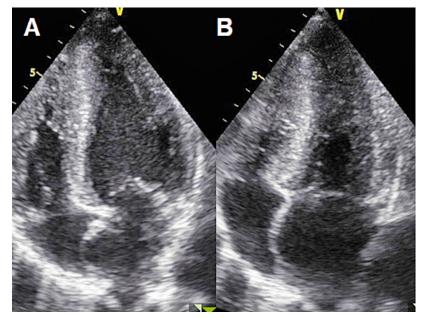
Transthoracic echocardiography, apical four-chamber view, showing left ventricular hypertrophy predominantly at the apex. A: end-diastolic still frame, B: end-systolic still frame
